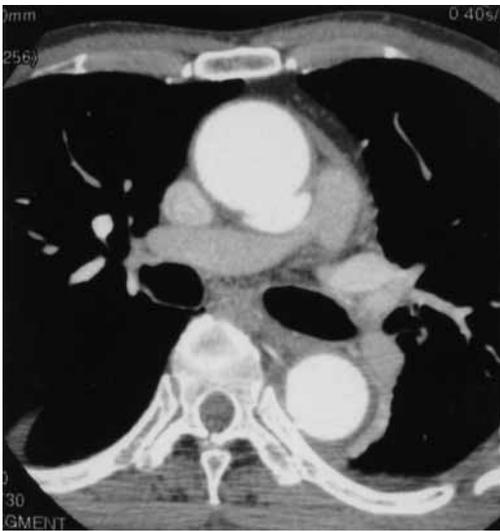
Computed tomography (CT) showed an intramural or medial hematoma as a small ulcer-like projection (ULP) in the posterior aspect of the ascending aortic wall, but revealed no intimal flap, false lumen or aortic aneurysm.
